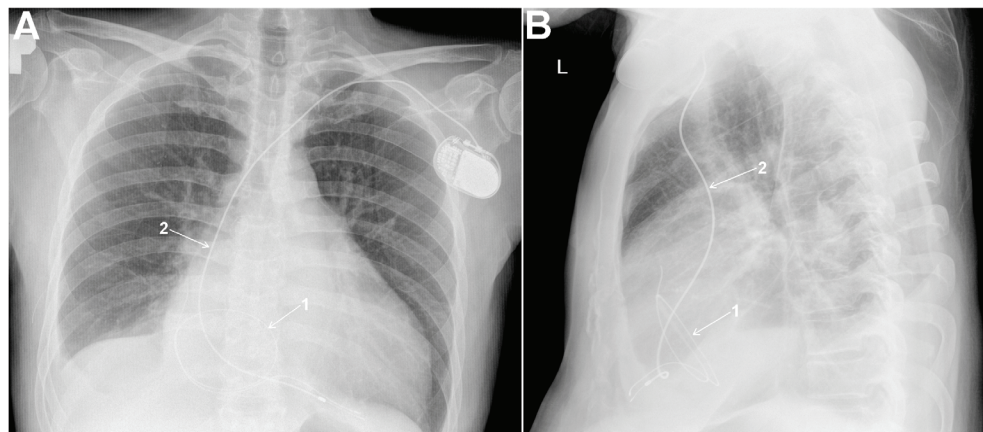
The lead dropped in and coiled in the heart in the X-ray chest scan in a patient with PM.
